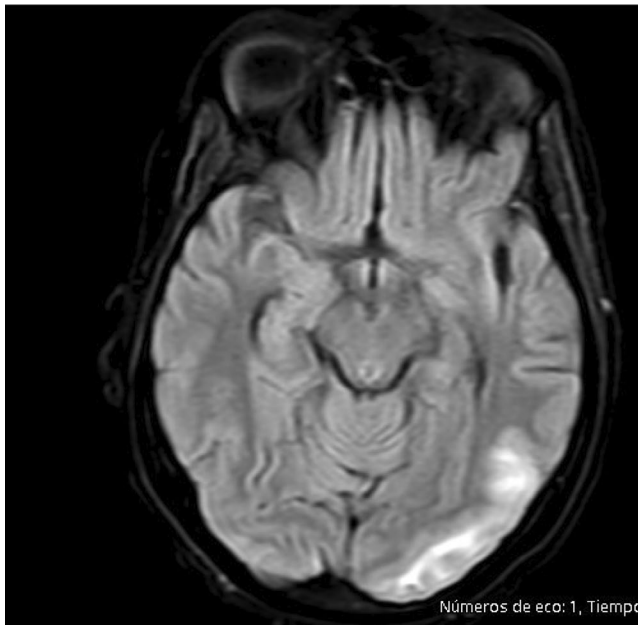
Left temporooccipital hypersignal, FLAIR.
